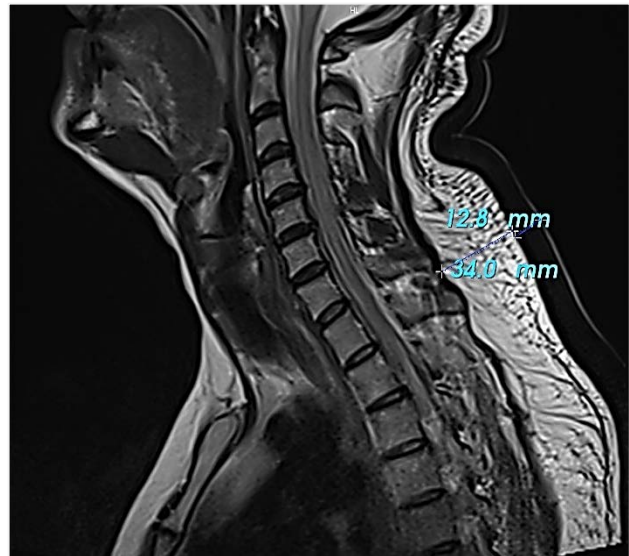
Sagittal T2-weighted MRI image demonstrates thickening of the skin and subcutaneous fat tissue
